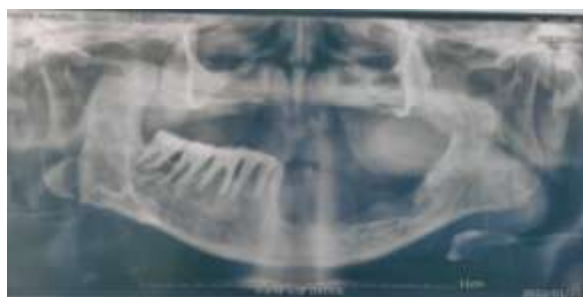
Orthopantomogram of patient
